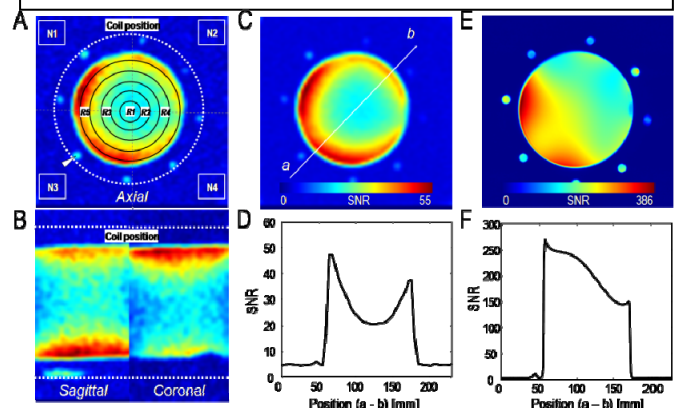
SNR measurement of proton and sodium MR image. A and B, Axial and Sagittal and coronal view of sodium image. ROIs are defined as cylindrical regions with different radius. Reference markers (white-arrowhead) are attached to the inner wall of sodium coil cylindrical frame (white-dotted circle). C and E, SNR map of sodium and proton image. D and F, SNR profile of sodium and proton image following a-b white line in C.
